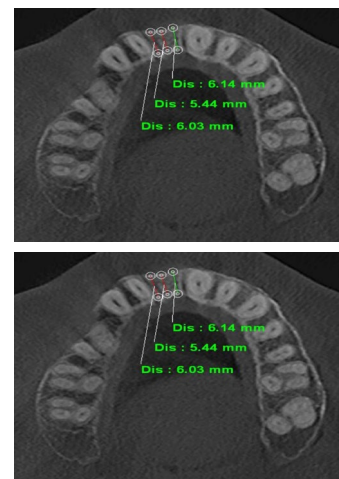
CBCT imaging on Axial view.
